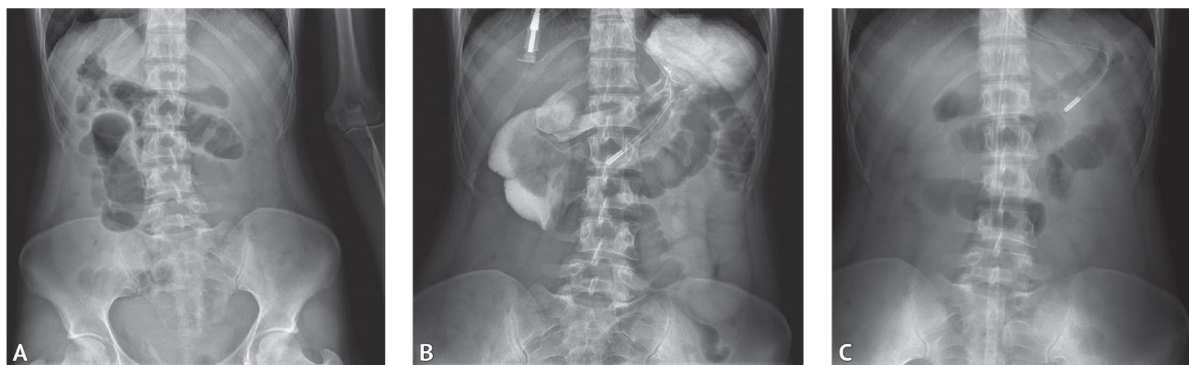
Plan X-ray of the abdominal organs (A); B — at the beginning of the study of the passage of a water-soluble contrast agent along the gastrointestinal tract; C — 4 hours after the start of the study
